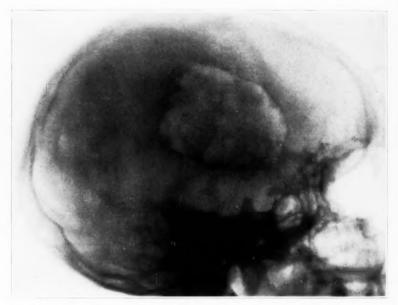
Roentgenogram of the skull of King's patient. Note that the appearance is almost identical with that shown in figure 1.
